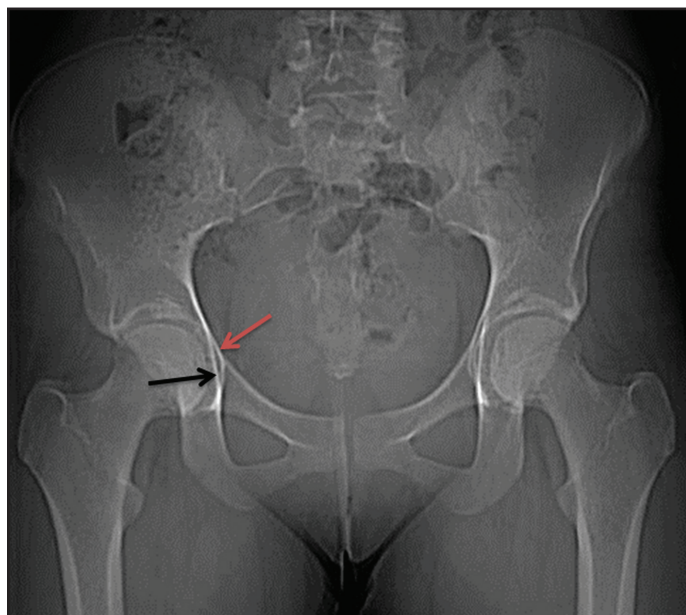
Anteroposterior pelvic radiograph demonstrating coxa profunda.
